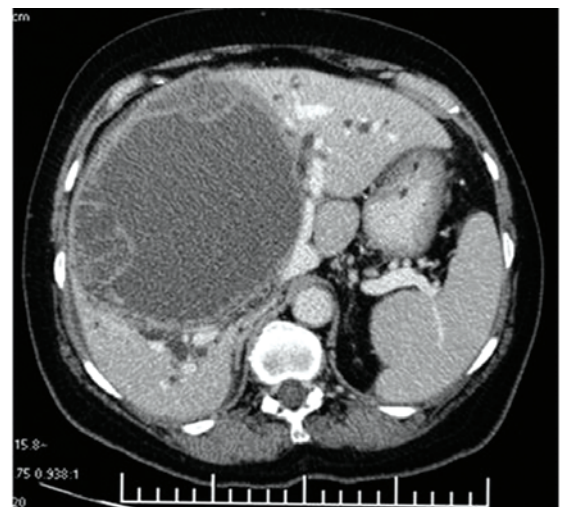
Abdominal computed tomography scan in case of biliary cystadenocarcinoma
